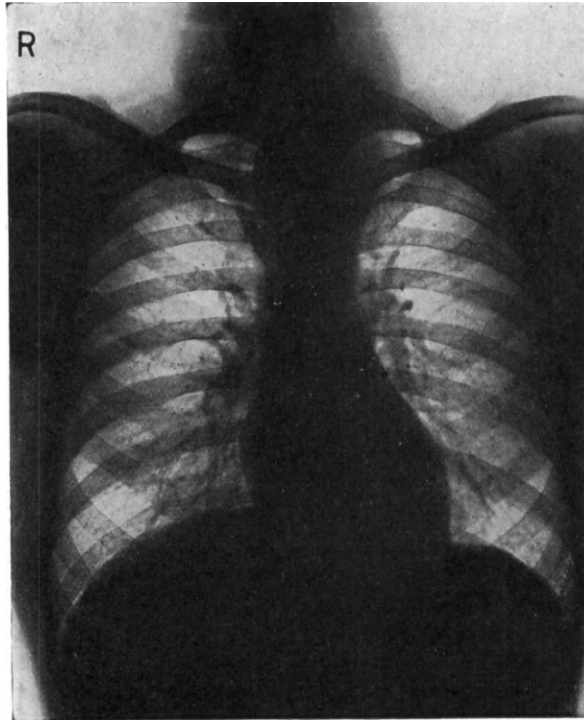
X-ray showing trachea pushed to right by a large substernal goitre.
